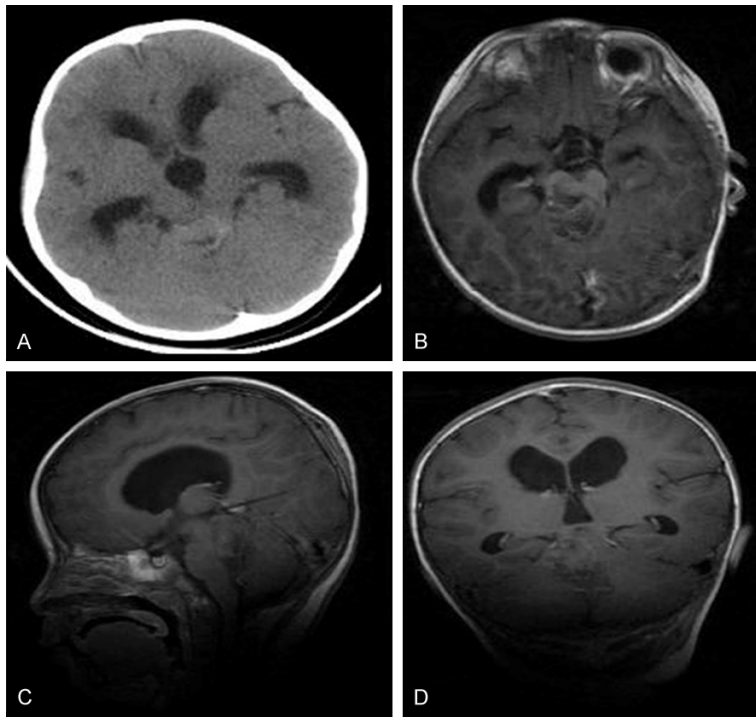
A: CT imaging revealed an isodense pineal area mass lesion, but there is slight hyperdense in it. B-D: MRI showed isointense to slight hypointense on T1-weighted sequences and displayed a heterogeneous contrast enhancement.
